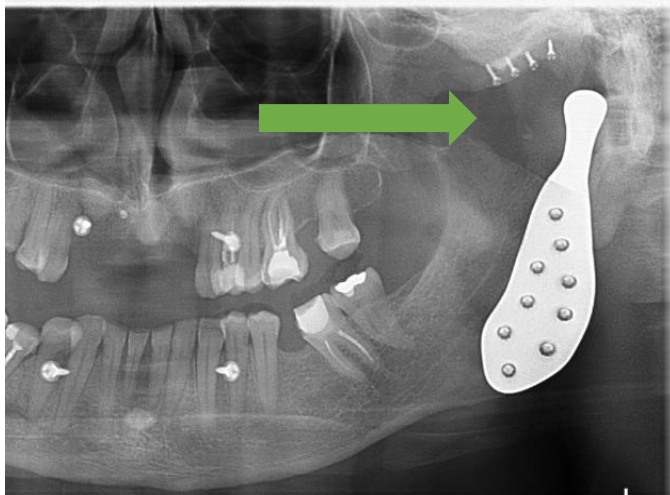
Orthopantomogram presenting displacement of the implant (green arrow). Radiological examination was performed 2 months after the surgery (RadiAnt DICOM Viewer 2025.2).
